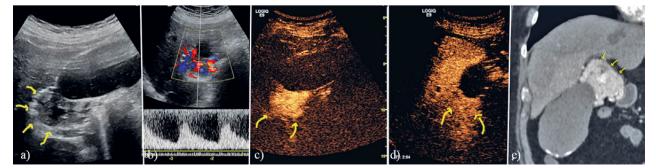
Cholecystic artery malformation (arrows). Ultrasonographic exploration in grayscale (a), Color and spectral Doppler (b), CEUS in arterial (c) and venous (d) phases. CT appearance (arterial phase) (e).
